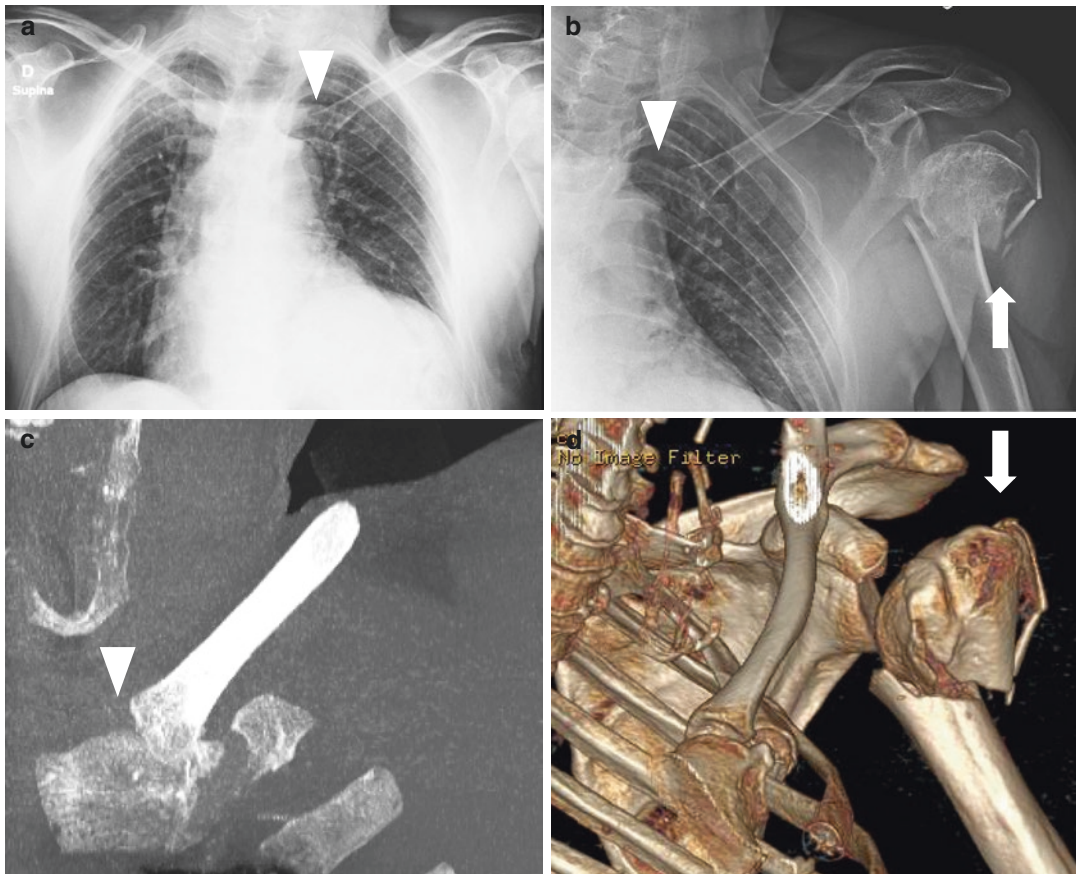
Chest X-rays showing posterior dislocation of the left clavicle (arrowhead in a). Shoulder X-ray film of the same patient demonstrating subluxation of the left sternoclavicular joint (arrowhead in b) and left humeral head
